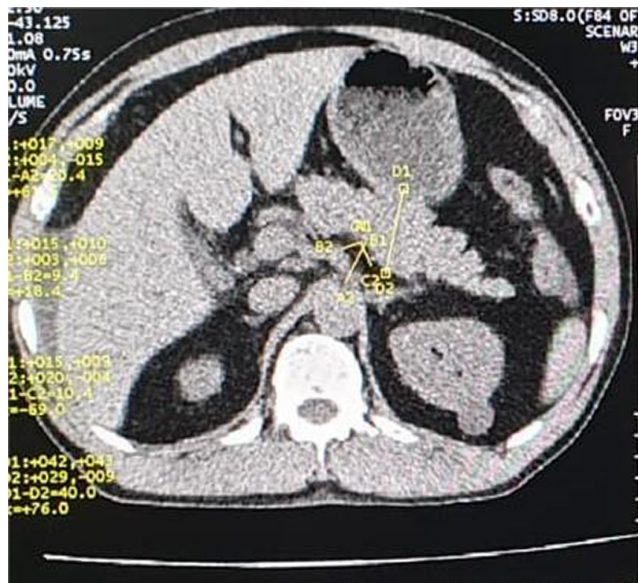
CT Scan of abdomen showing bulky pancreas.
